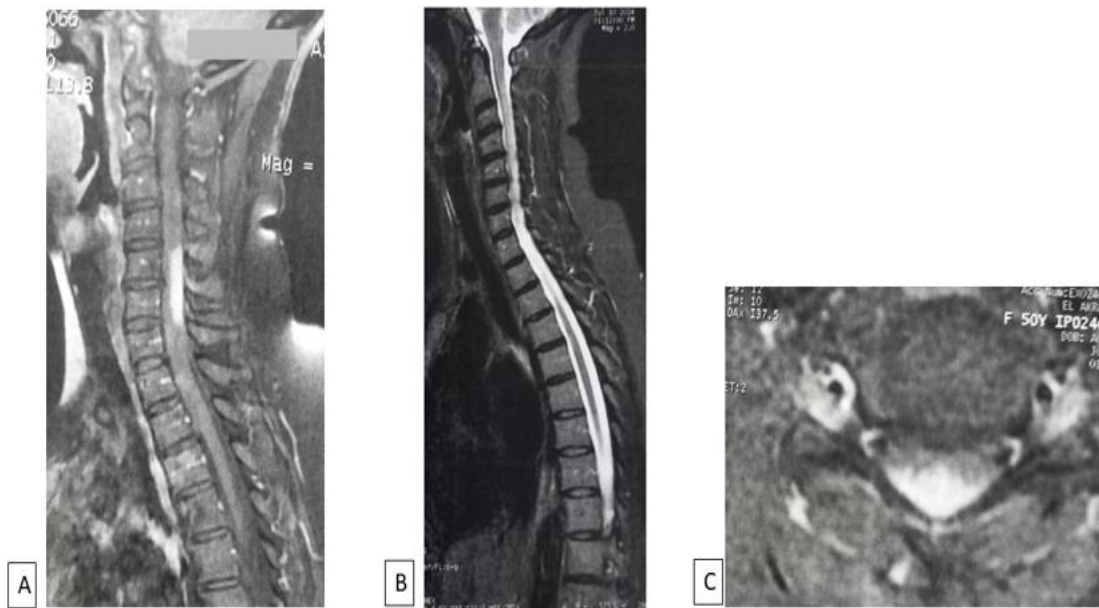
T1-weighted sagittal and axial images of the cervical spinal cord showed a contrast enhancement of a well-circumscribed lesion of the posterior horn, suggesting astrocytoma (A, C). T2-weighted sequence, showed hyperintense lesion, extending from C3–C7 (B).
